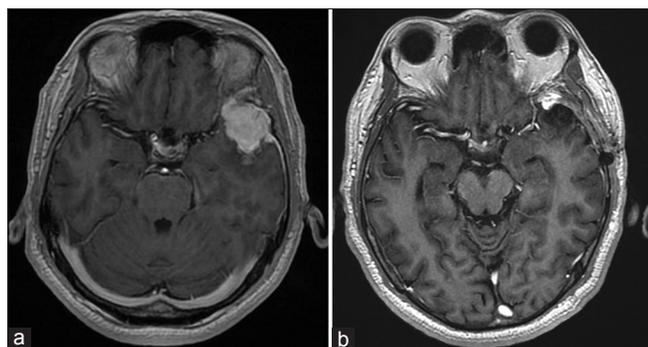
(a) Preoperative magnetic resonance imaging of the brain showing a left lateral sphenoid wing meningioma. (b) Postoperative magnetic resonance imaging image showing a Simpson II resection
